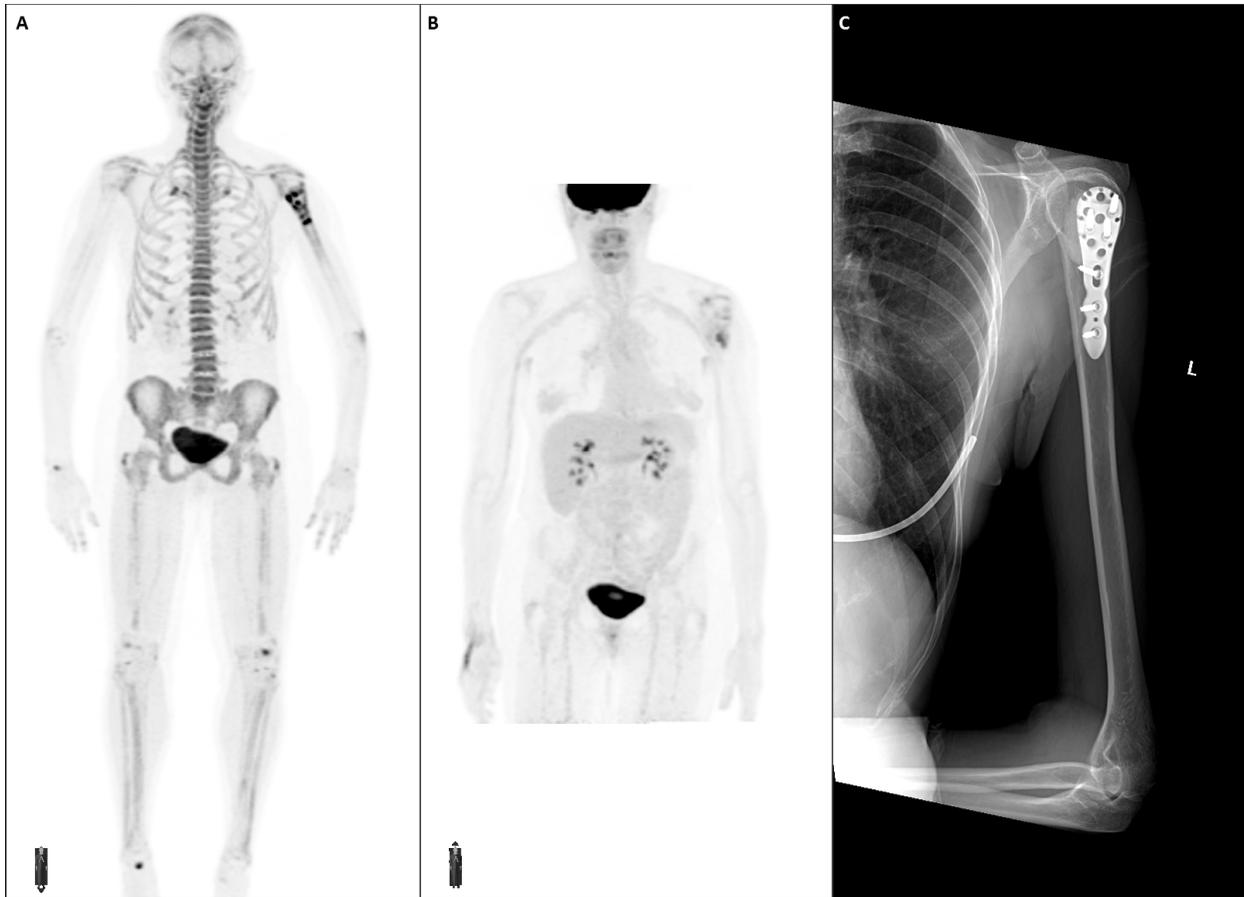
A 58-y-old women with history of metastatic colorectal cancer. Lytic metastasis to the left proximal humerus status post radiation therapy and fixation hardware. Anterior maximum intensity projection (MIP) view of the ^{18}F -NaF (A) and ^{18}F -FDG (B) PET scans shows heterogeneous increased tracer uptake in the left proximal humerus secondary to bone remodeling. No other area of abnormal tracer activity seen elsewhere. (C) X-ray of the left humerus show cement and fixation hardware.
